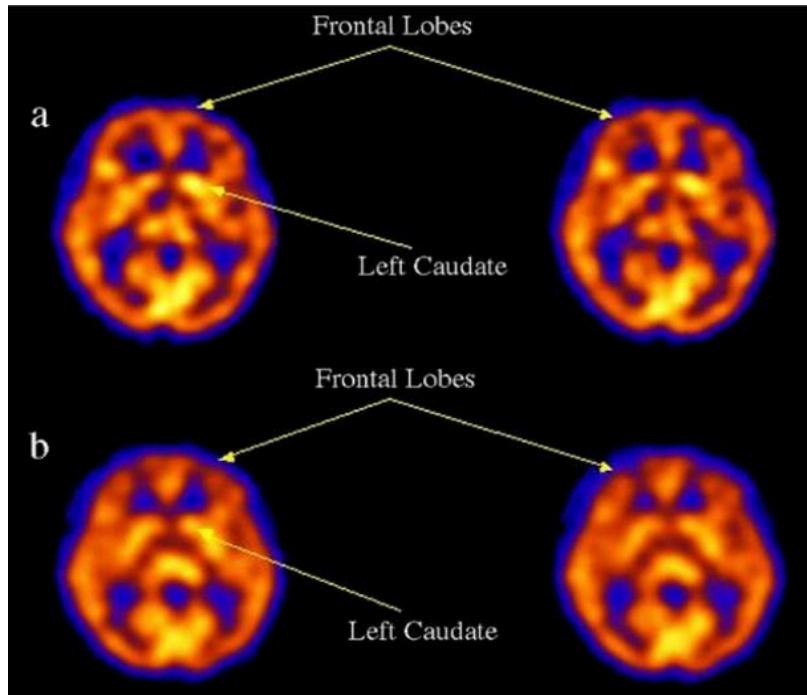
SPECT scans of participants in singing (a) and glossolalic (b) states. There are decreased rCBF levels in the right prefrontal cortex and left caudate via blood flow coloration. Red represents greater blood flow and blue less [3].
